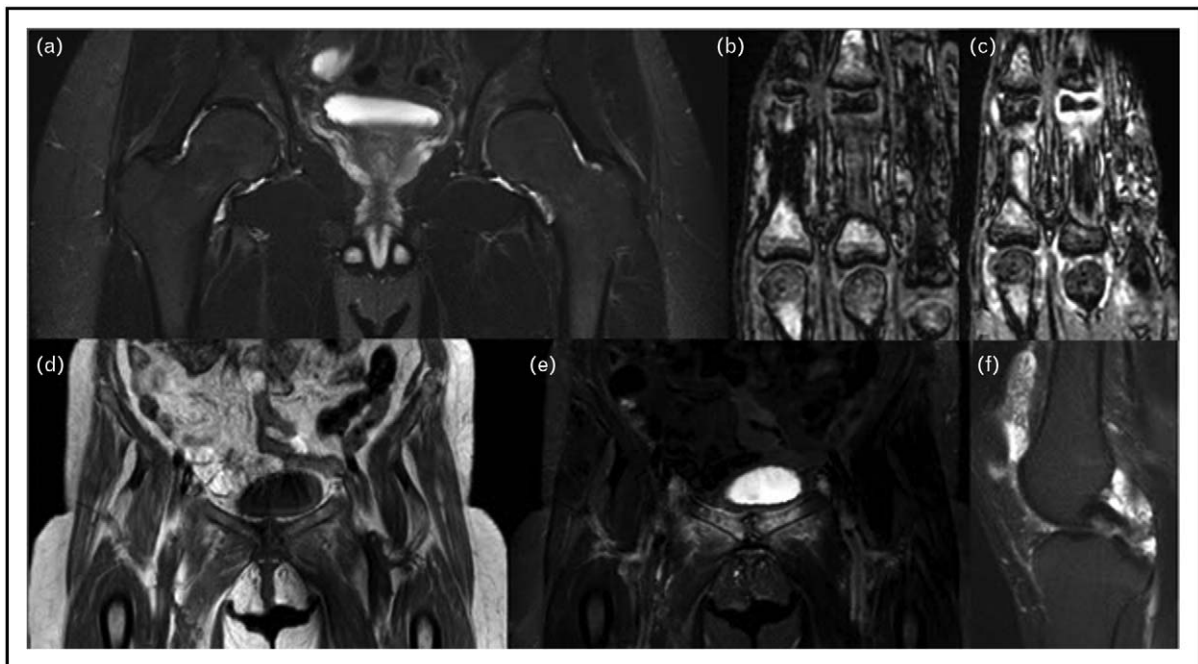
Whole-body magnetic resonance imaging (WB-MRI). Whole-body MRI images: (a) mild bilateral hip joint synovitis (coronal short tau inversion recovery (STIR) image); (b–c) synovitis in metacarpophalangeal and proximal interphalangeal joints (Coronal T1-weighted pre and postcontrast images); (d–e) bilateral severe soft tissue inflammation and bone marrow edema at the symphysis (coronal T1-weighted and STIR images); and (f) severe knee joint synovitis and effusion (STIR image).
